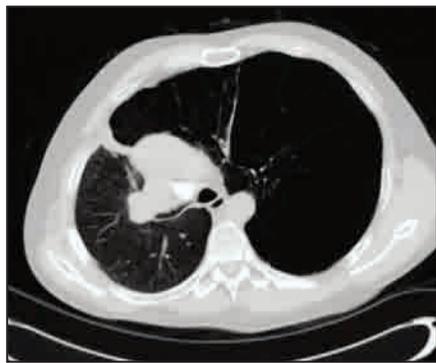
Preoperative CT scan showing mediastinal shift and graft compression.
